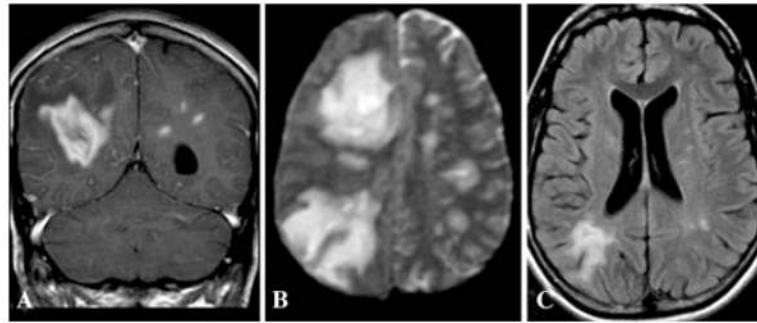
MRI features of acute disseminated encephalomyelitis (ADEM). (A) Coronal T1-weighted postgadolinium image showing enhancing lesions in the right more than left hemispheres. (B) Axial zero-B MRI demonstration of the multiple lesions. (C) FLAIR MRI 6 months after marked clinical recovery shows much improved areas of hyperintensity.
